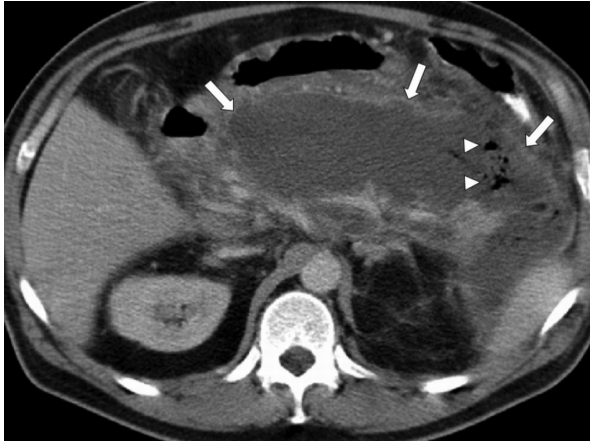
Contrast-enhanced CT of a patient with AP 36 days after onset of symptoms. The body and tail of the pancreas are largely non-enhancing. Adjacent to the pancreatic bed is a large collection with predominately fluid like attenuation. Because of the gas bubbles some would call this a 'pancreatic abscess' whereas others would name this 'infected pancreatic necrosis'.
